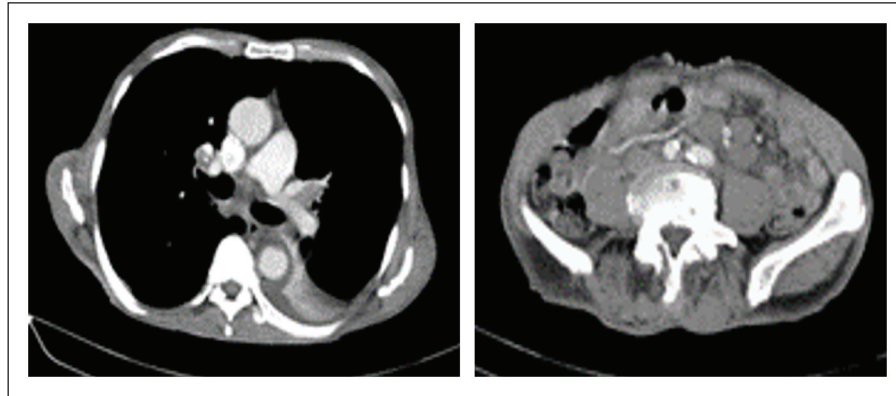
Thoraco-abdominal CT scan—mediastinal, hilar, and cervical lymphadenopathy (left); apical and basal consolidation, left lower lobe consolidation and left moderate pleural effusion, lymph node biopsy—necrotizing inflammation (right).
